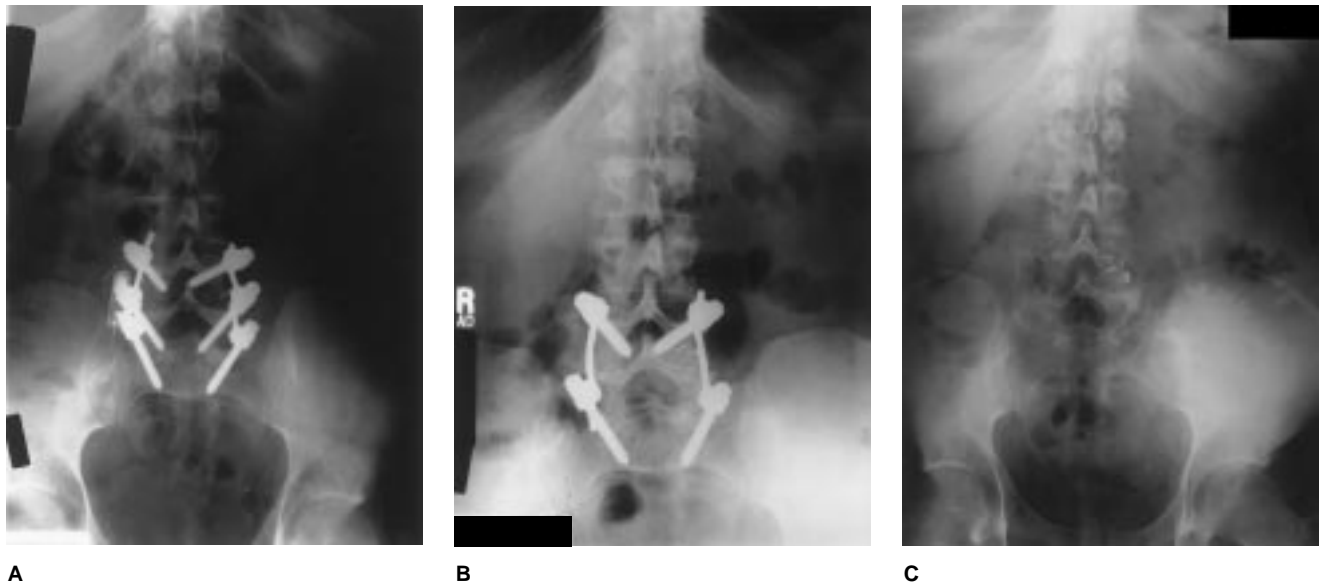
A, An attempted posterolateral fusion involving internal fixation resulted in pain and radiographically apparent pseudarthrosis. B, The fixation was found to be loose and was revised. Autologous bone was placed across the pseudarthrosis at L4-S1. At the same sitting, the L4-L5 level was approached anteriorly, and an anterior lumbar interbody fusion was performed. C, The fixation device was subsequently removed, and the fusion was found to be solid.
